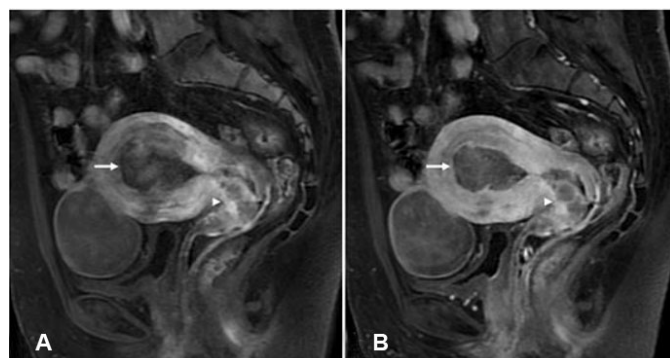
Contrast-enhanced magnetic resonance imaging (MRI) fat-suppressed T1-weighted images. (A) Early-phase contrast fat-suppressed T1-weighted images; sagittal section showing a stronger and more heterogeneous enhancement in the cervical mass compared with the mass in the corpus of the uterus. (B) Delay-phase contrast fat-suppressed T1-weighted images; sagittal section showing a relatively stronger heterogeneous enhancement in the cervical mass compared with the mass in the corpus of the uterus.
